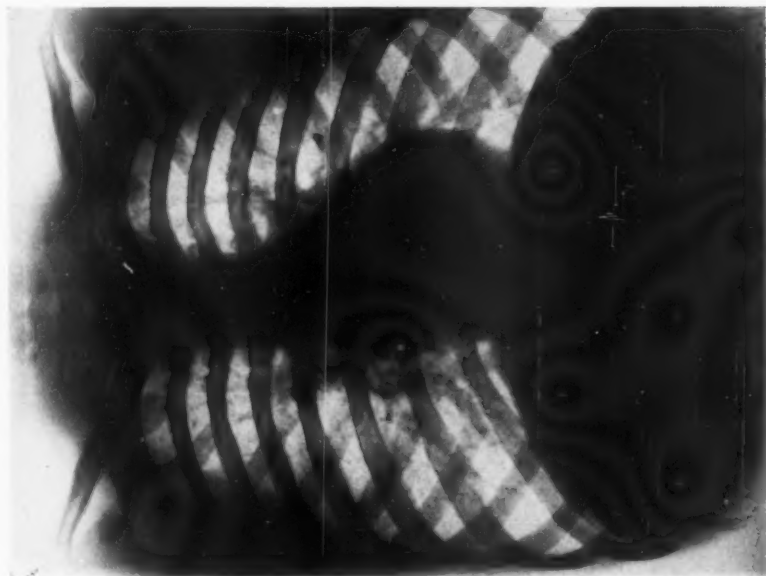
An ordinary radiograph.
